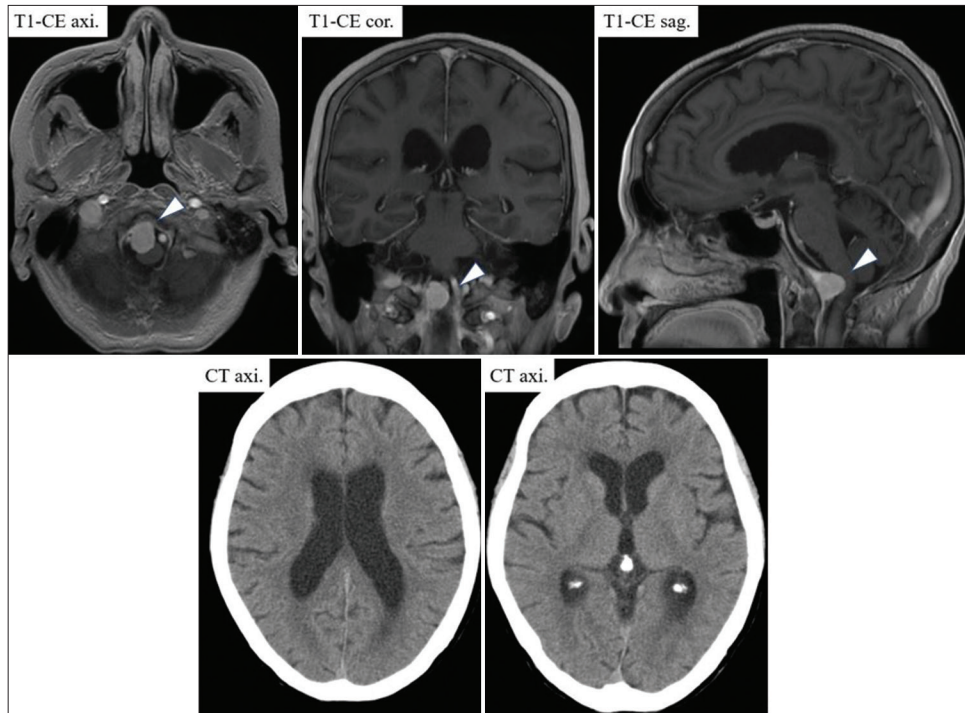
Spinal magnetic resonance imaging revealed an 18-mm tumor lesion with a contrast effect on the ventral side of the foramen magnum (arrowhead); moreover, computed tomography showed no hydrocephalus (Evans index: 0.29).
